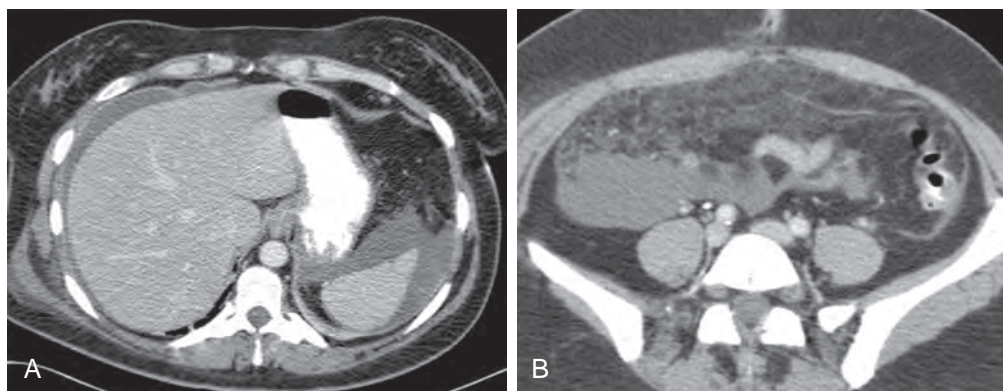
Bile leakage inducing bile peritonitis A. Ten days after LC, CT shows free fluid, compatible with bile, around the spleen and the liver. B. Pelvic CT shows a large amount of free fluid and marked infiltration of the mesentery and omentum, indicating infected bile.
